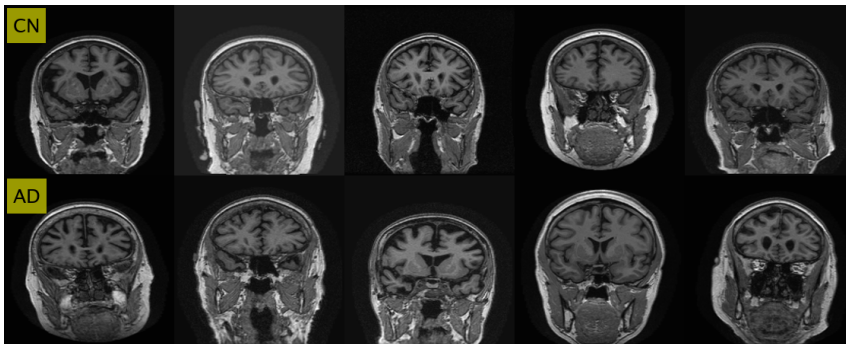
Coronal plane: MRI slice Nr. 87 for CN and AD. Second best selection according to histogram descriptors.
